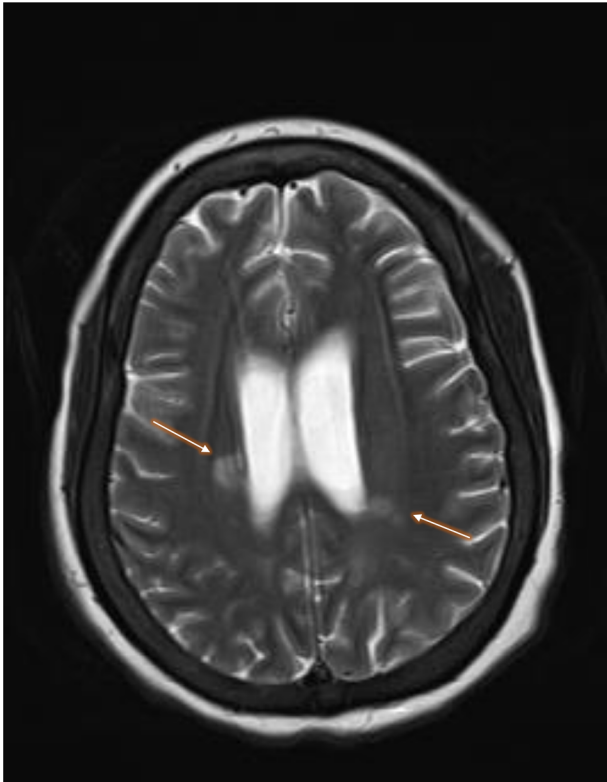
T2-weighted magnetic resonance imaging of the brain showing enhanced lesions (arrows) and enlarged lateral ventricles.
